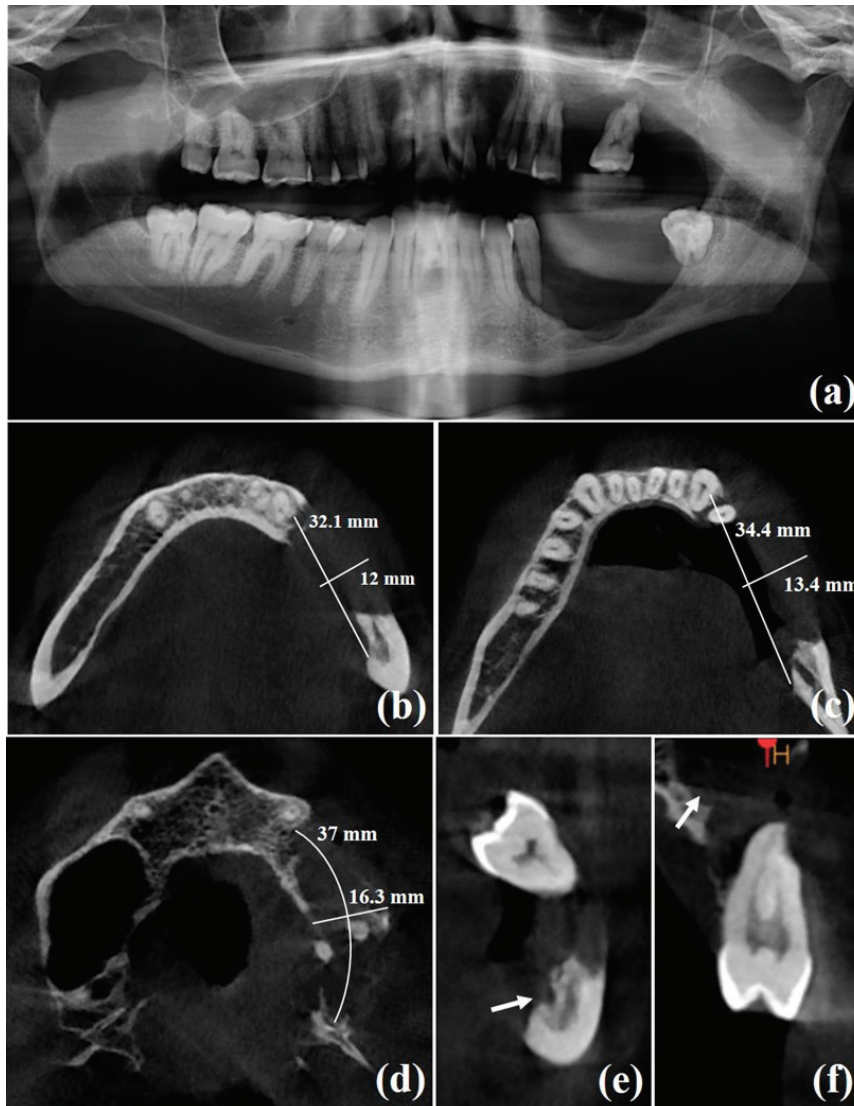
The radiographic aspect of Case 1. (a) Panoramic radiography showing scooped-out shaped bone destruction in left maxillary and mandibular posterior regions. (b, c) Axial CBCT sections revealing severe alveolar bone loss in the left mandibular posterior area. (d) Axial CBCT section of maxilla displaying extensive bone destruction in the left maxillary posterior region. Sagittal CBCT sections showing (e) the involvement of the inferior alveolar canal (arrow), and (f) mucosal thickening in the left maxillary sinus (arrow).
